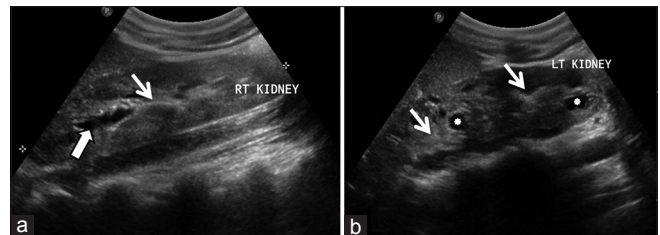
(a and b) Ultrasound images showing bilateral enlarged kidneys, echogenic medullary regions (arrows), cortical cysts (asterix) and caliectasis (arrowhead)
